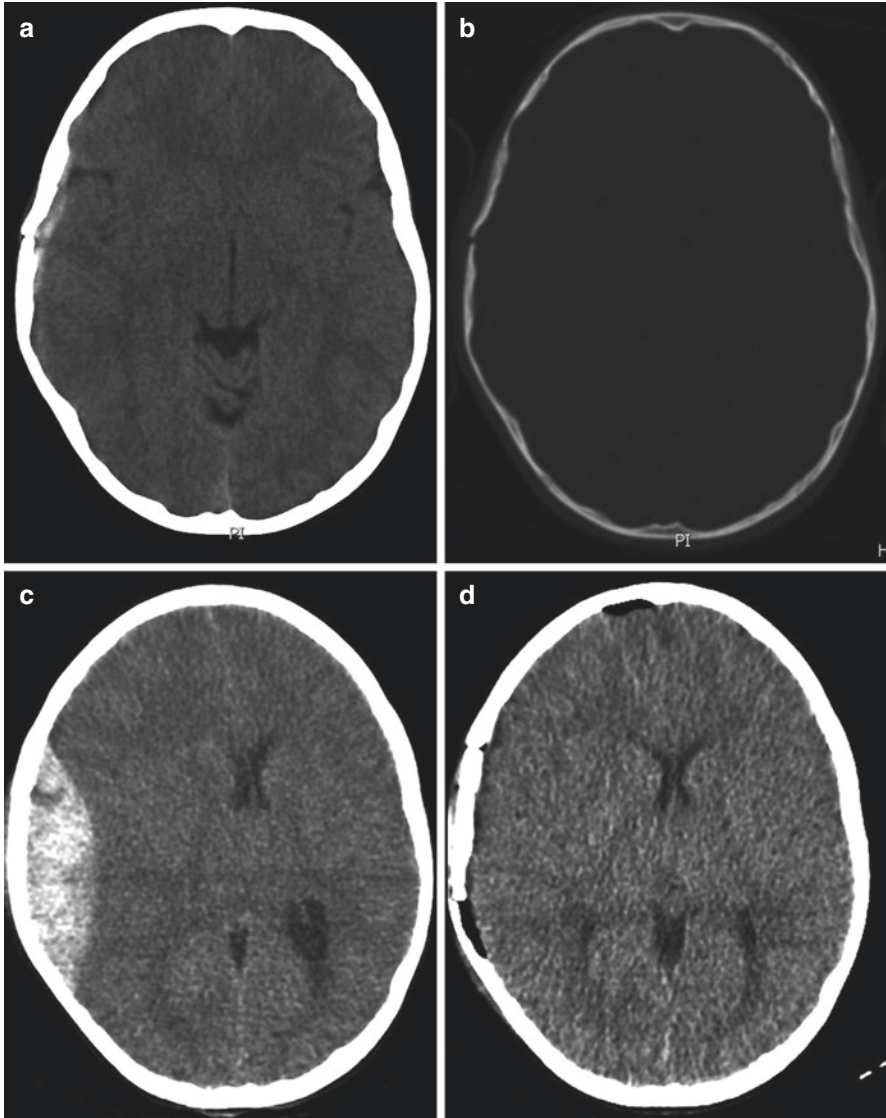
(a) A 6-year old boy presented in the emergency department after a fall. Brain CT revealed a small temporoparietal EDH and an overlying linear skull fracture (b). The patient presented alert with normal vital signs. (c) Three hours later because of altered level of consciousness and vomiting a repeat CT scan was performed and revealed an increase of EDH thickness and midline shift. The patient was operated on via a temporoparietal craniotomy. (d) Postoperative CT scan. The patient had a full recovery
